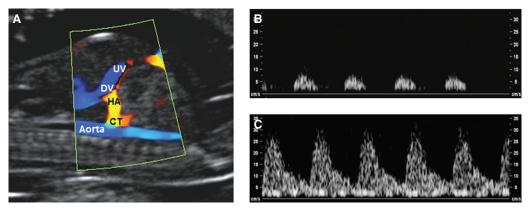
A: Right ventral midsagittal view of a fetus at 12 weeks demonstrating the umbilical vein (*UV*), ductus venosus (*DV*), descending aorta, hepatic artery (*HA*), and celiac trunk (*CT*). The peak systolic velocity in the waveform from the fetus with trisomy 21 (C) is much higher than in a euploid fetus (B).
